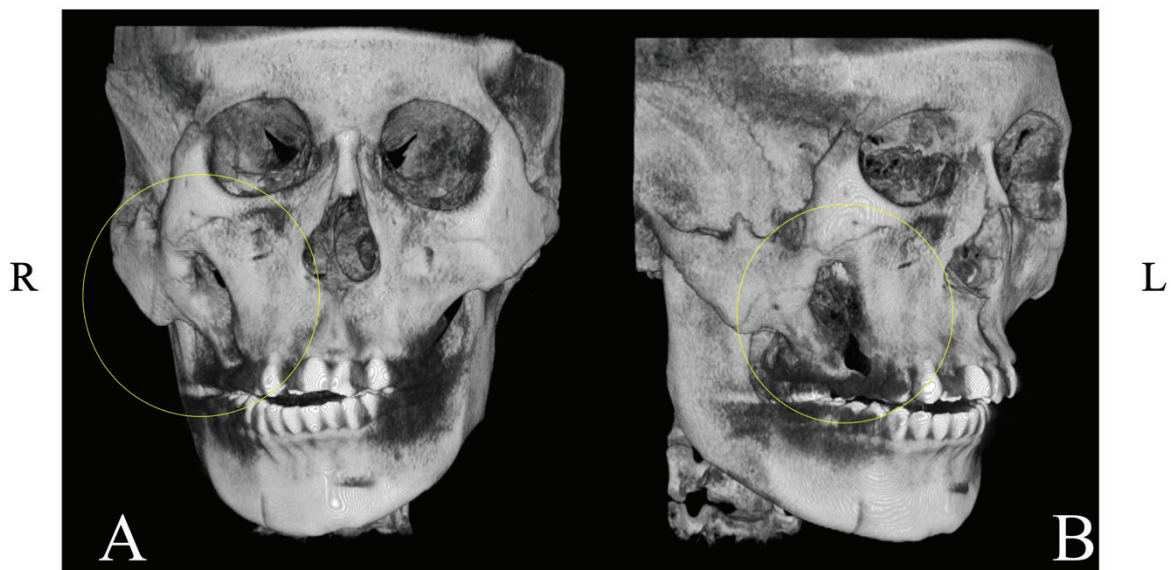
Three-dimensional CBCT reconstruction in frontal (A) and oblique (B) views show the extent of Tessier cleft 5.
